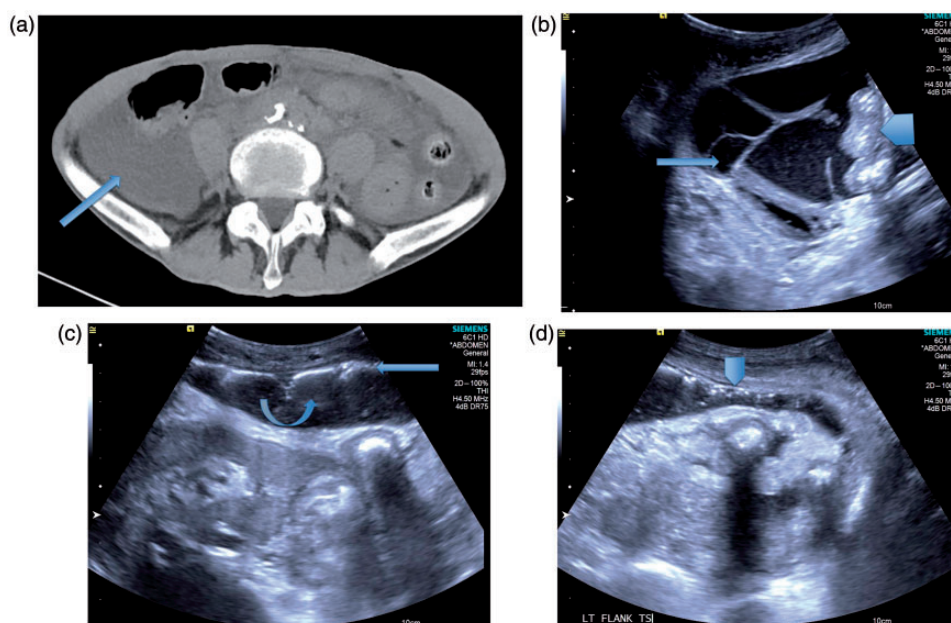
(a) CT scan. Generalised ascites noted (arrow) but no free gas. (b) US scan. Complex fluid with internal septations and low level echoes (arrow) indicative of an exudate. Arrowhead points to matted bowel loops. (c and d) Linear hyper-echoic arcs (arrow) with posterior reverberation artefact (curved arrow) and mottled specks of hyper-echoic foci (arrowhead) in the non-dependant aspect beneath the abdominal wall correspond to pneumoperitoneum.
